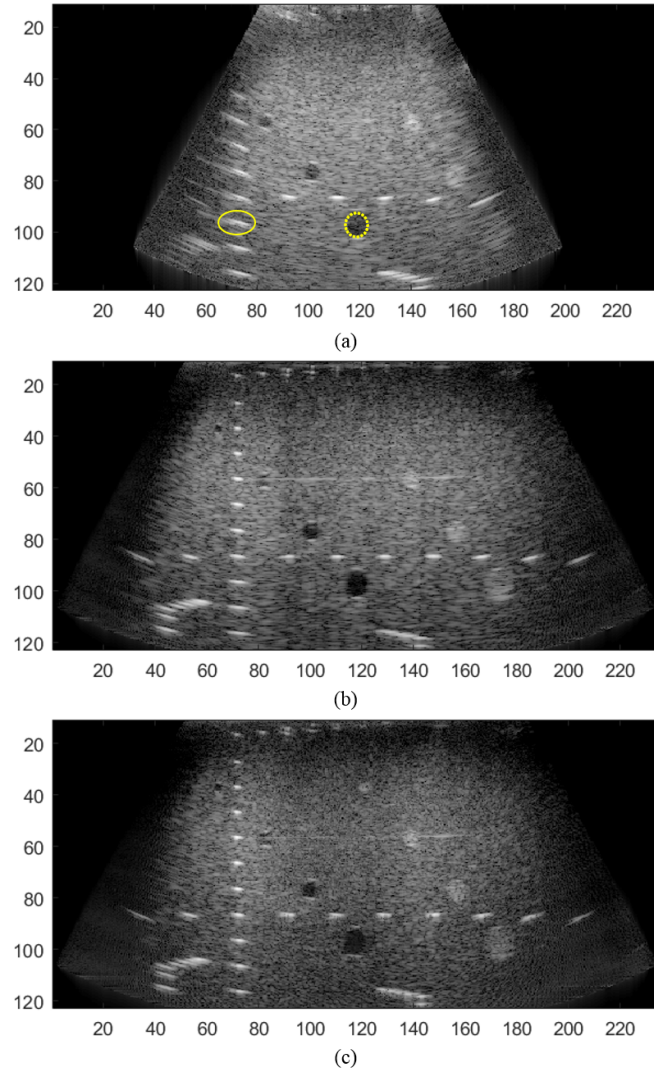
(a) Single pose B-mode ultrasound image. (b-c) STRATUS images synthesized the range of 10 mm (b) and 60 mm (c) motion data. The yellow solid circle region was used for FWHM and SNR measurement, and the dot circle region was used for contrast measurement.
